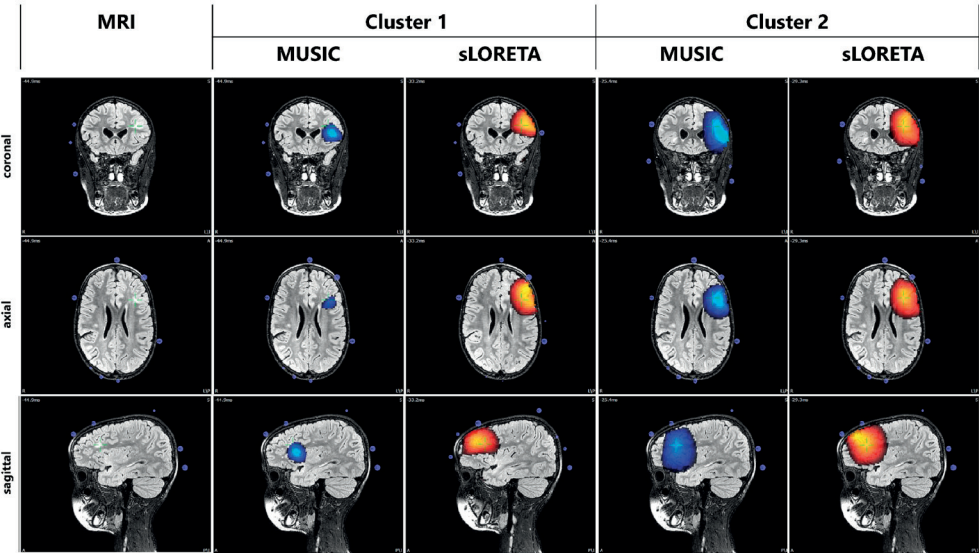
HR-ESI results from patient 3 indicating a left frontal focus. HR-ESI: high resolution electric source imaging; MUSIC: multiple signal classification; sLORETA: standardized low-resolution brain electromagnetic tomography. Fluid attenuated inversion recovery (FLAIR) MRI shows multiple bilateral subcortical tubers. A large tuber is located in the left fronto-lateral region (marked with crosshair). HR-ESI resulted in two spike clusters. MUSIC and sLORETA results for each cluster are depicted by blue and red blobs and were all located in or near the tuber region with varying spatial accuracy. Interictal EEG was multifocal by showing bilateral frontal and temporal activity with a predominant left fronto-temporal focus. Ictal EEG suggested a widespread left fronto-centro-parietal focus. Resection of two tubers in the left frontal area resulted in seizure freedom (Engel 1a) at 13 months follow up.
